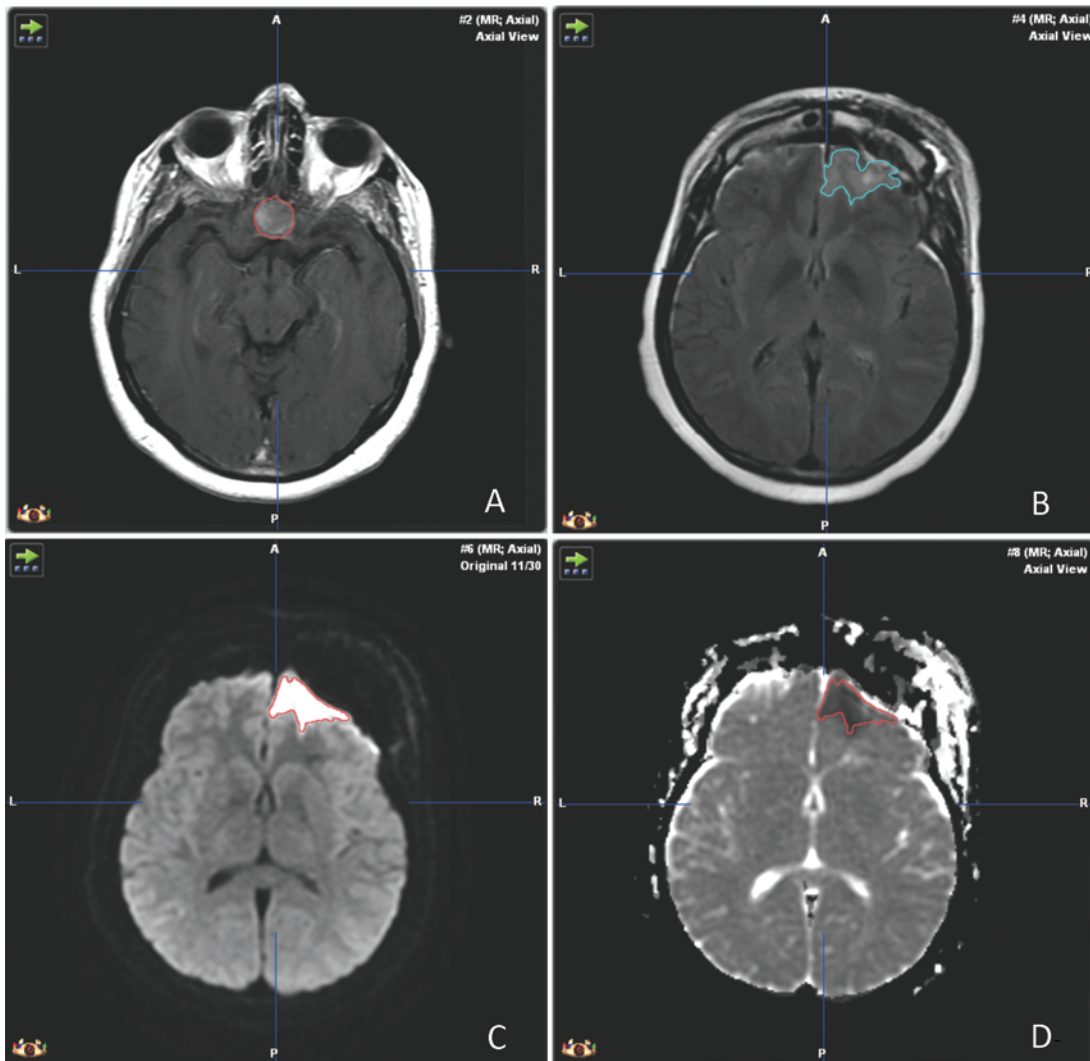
Representative volumetric analysis of postoperative FLAIR and DWI after a TCA resection. A: Axial T1-weighted image with contrast demonstrating preoperative tumor (red). B: Postoperative FLAIR hyperintensity secondary to retraction injury (blue). This area of FLAIR hyperintensity was not present on preoperative imaging (not shown). C and D: DWI hyperintensity (red, C) that also shows diffusion restriction on the ADC map (D). Figure is available in color online only.
